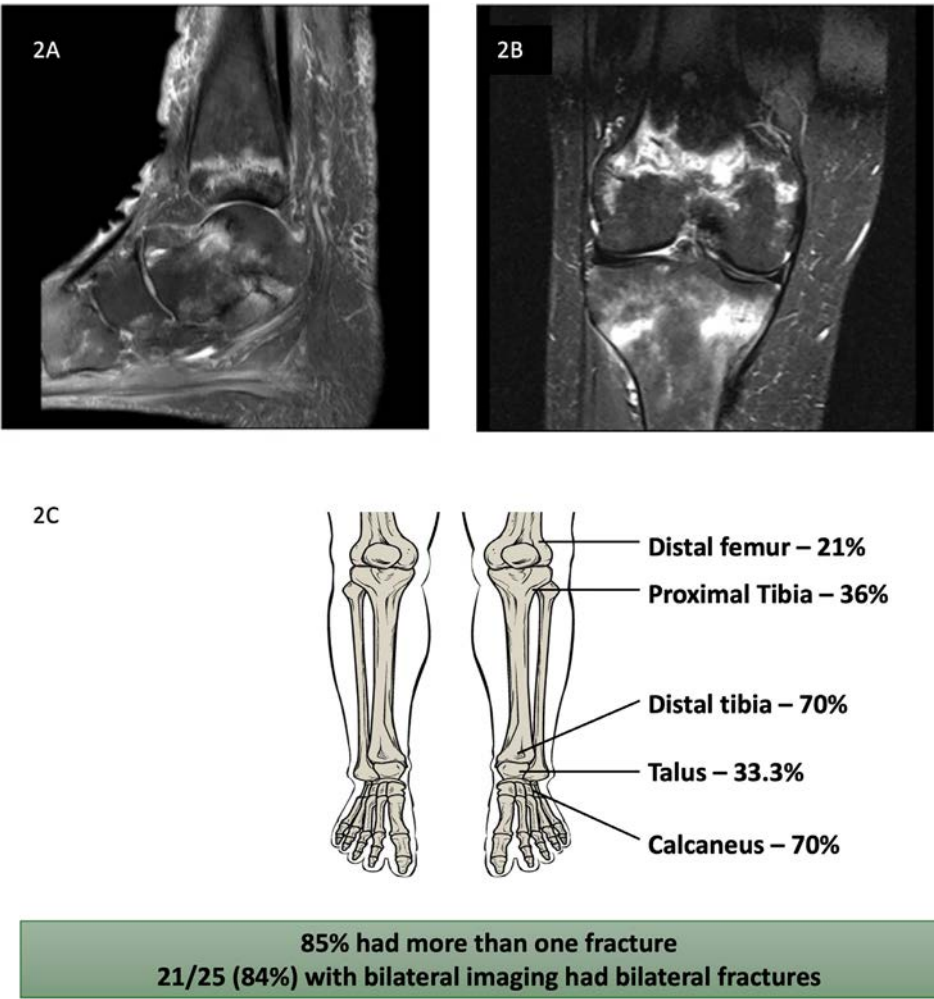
(A and B) MTXO fractures. (A) MRI of the left ankle (sagittal Proton Density Fat Saturation (PDFS) sequence), showing an insufficiency fracture of the distal tibial metaphysis and a sagittal oblique fracture of the medial talus. (B) MRI T1 Turbo Inversion Recovery Magnitude (TIRM) sequence, highlighting bone oedema at the metaphyseal closure line of the femur and metaphyseal closure line of tibial condyles, denoting insufficiency fracturing. (C) Distribution and frequency of insufficiency fractures. MRI, magnetic resonance imaging.
